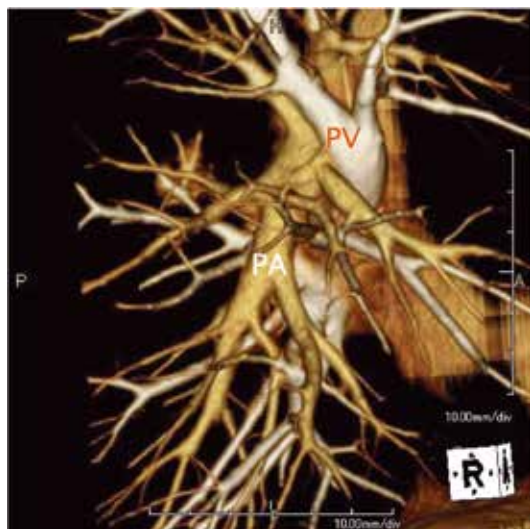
Three-dimensional computed tomography angiography. PA, pulmonary artery; PV, pulmonary vein.
